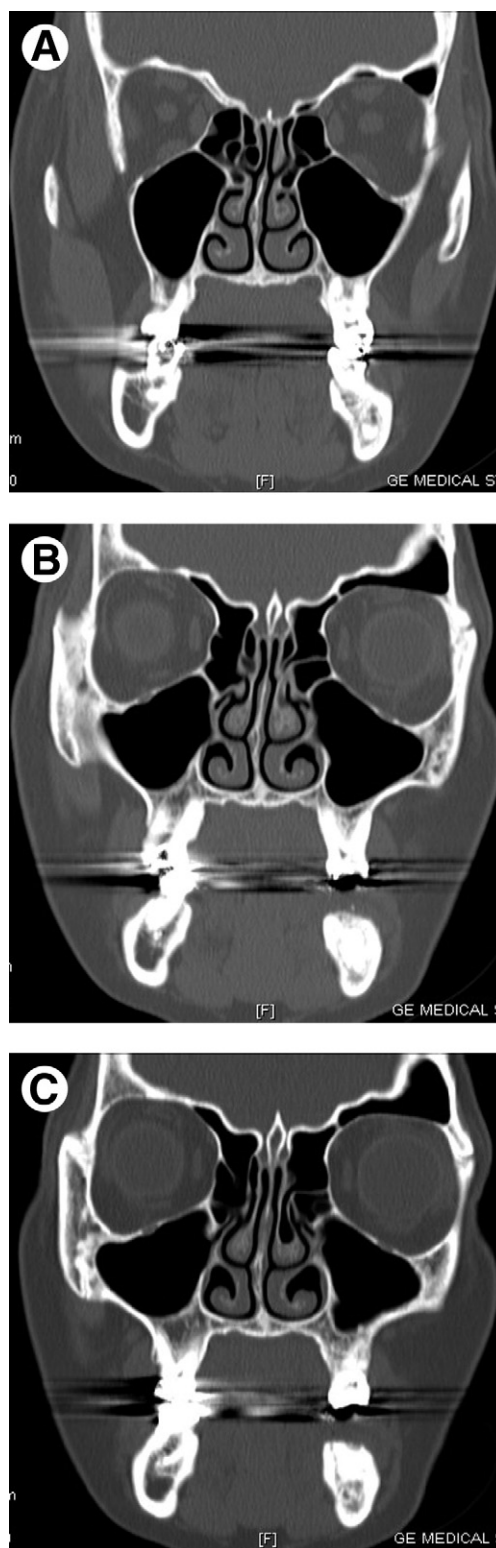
A, Coronal computed tomography scan showing mandibular canal proximal to allogeneic bone graft material. B, Coronal computed tomography scan demonstrating lack of mandibular canal due to obliteration of canal by bone graft material. C, Coronal computed tomography scan with evidence of presence of mandibular canal distal to bone graft material.
